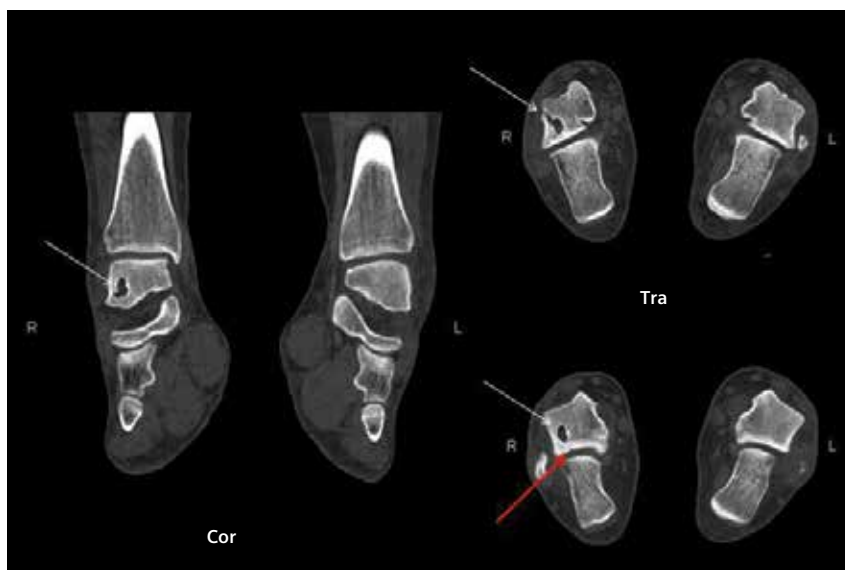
CT images show a cyst in the talus (white arrows) arising from the tunnel within the talus drilled during the previous surgery. Transverse CT slices show insufficiency fracture just posterior to the talar cyst (red arrow). The talo-calcaneal joint adjacent to the cyst shows slightly increased sclerosis and irregularities in the articular margin, which may be related to arthritic changes following stress on the joint secondary to insufficiency fracture.
